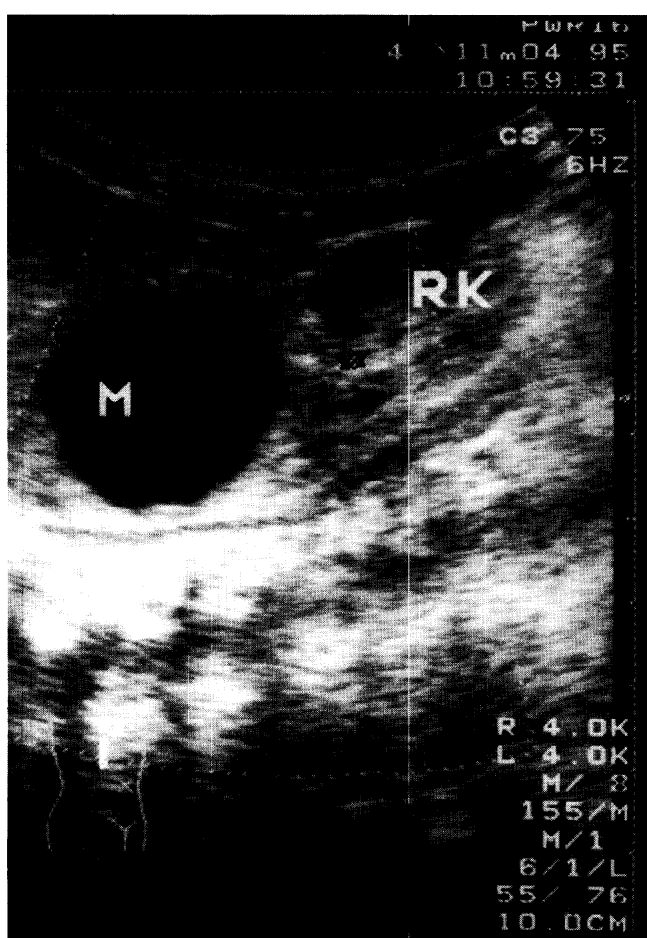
Neonatal sonogram at age 3 days, demonstrating a suprarenal cystic mass (M) and the right kidney (RK)
